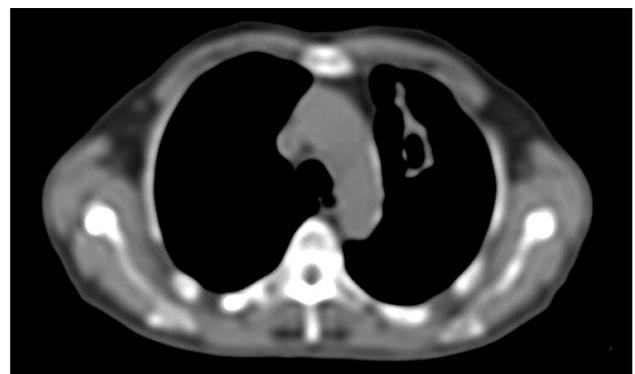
The FDG accumulating tumour in the left upper lobe was specified by positron emission tomography / computed tomography
